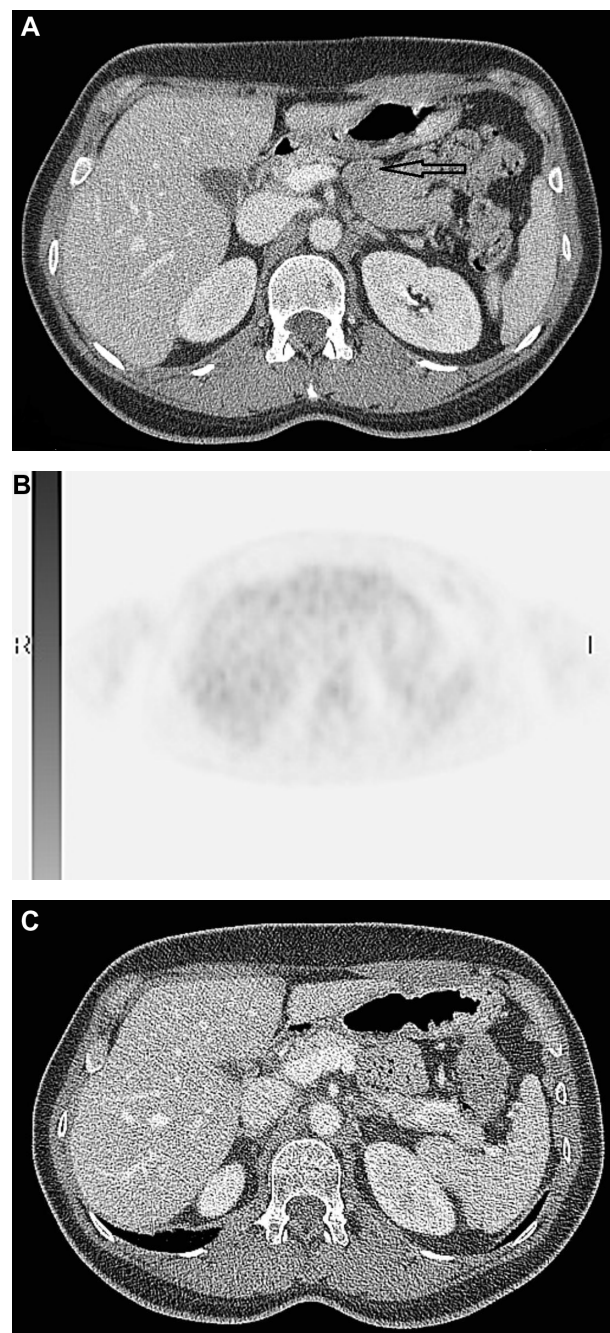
(A) Residual mass after the first four cycles. (B) Post-chemotherapy (first line) 18-FDGPET/CT showing complete metabolic response. (C) Complete radiologic response at the end of the first line of chemotherapy.
